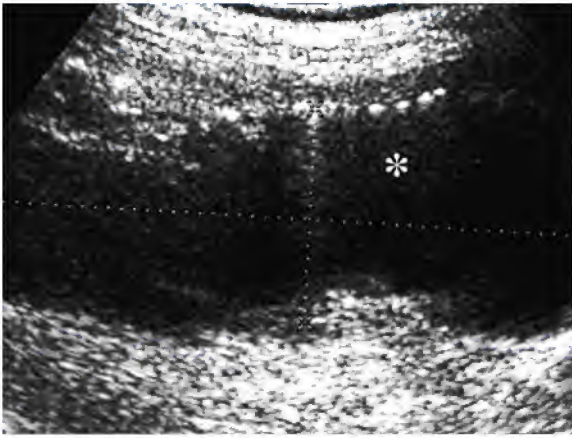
Image from a 40-year-old man obtained 16 days after simultaneous pancreas–kidney transplantation and graft pancreatitis. Annotations: pancreatic graft (*arrow*), donor's duodenum (*arrowhead*), renal graft (*black asterisk*), and perirenal fluid (*white asterisk*). a Contrast-enhanced multidetector CT shows homogeneous contrast enhancement of pancreatic graft (*arrow*). b Contrast-enhanced multidetector CT performed 5 days after initial CT displays inhomogeneous contrast enhancement and increasing size of pancreatic graft (*arrow*) indicating edematous pancreatitis
